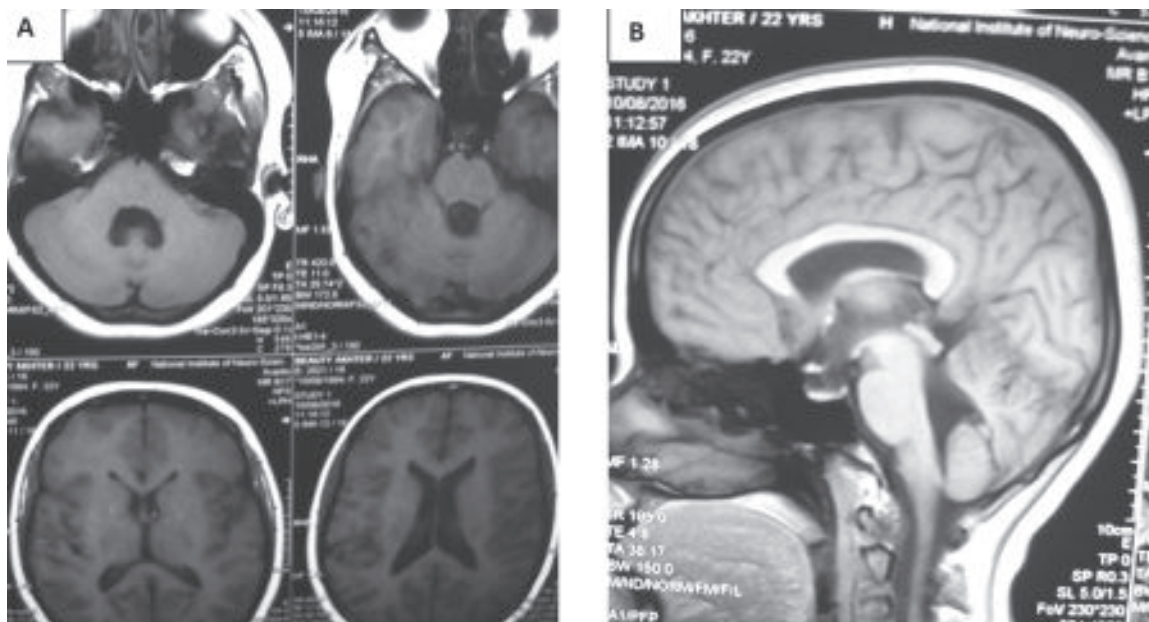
A,B: Magnetic resonance imaging (MRI) of brain, performed 4 and a half months after ETV showed significant shrinkage of each ventricle, improvement of the hydrocephalus.
